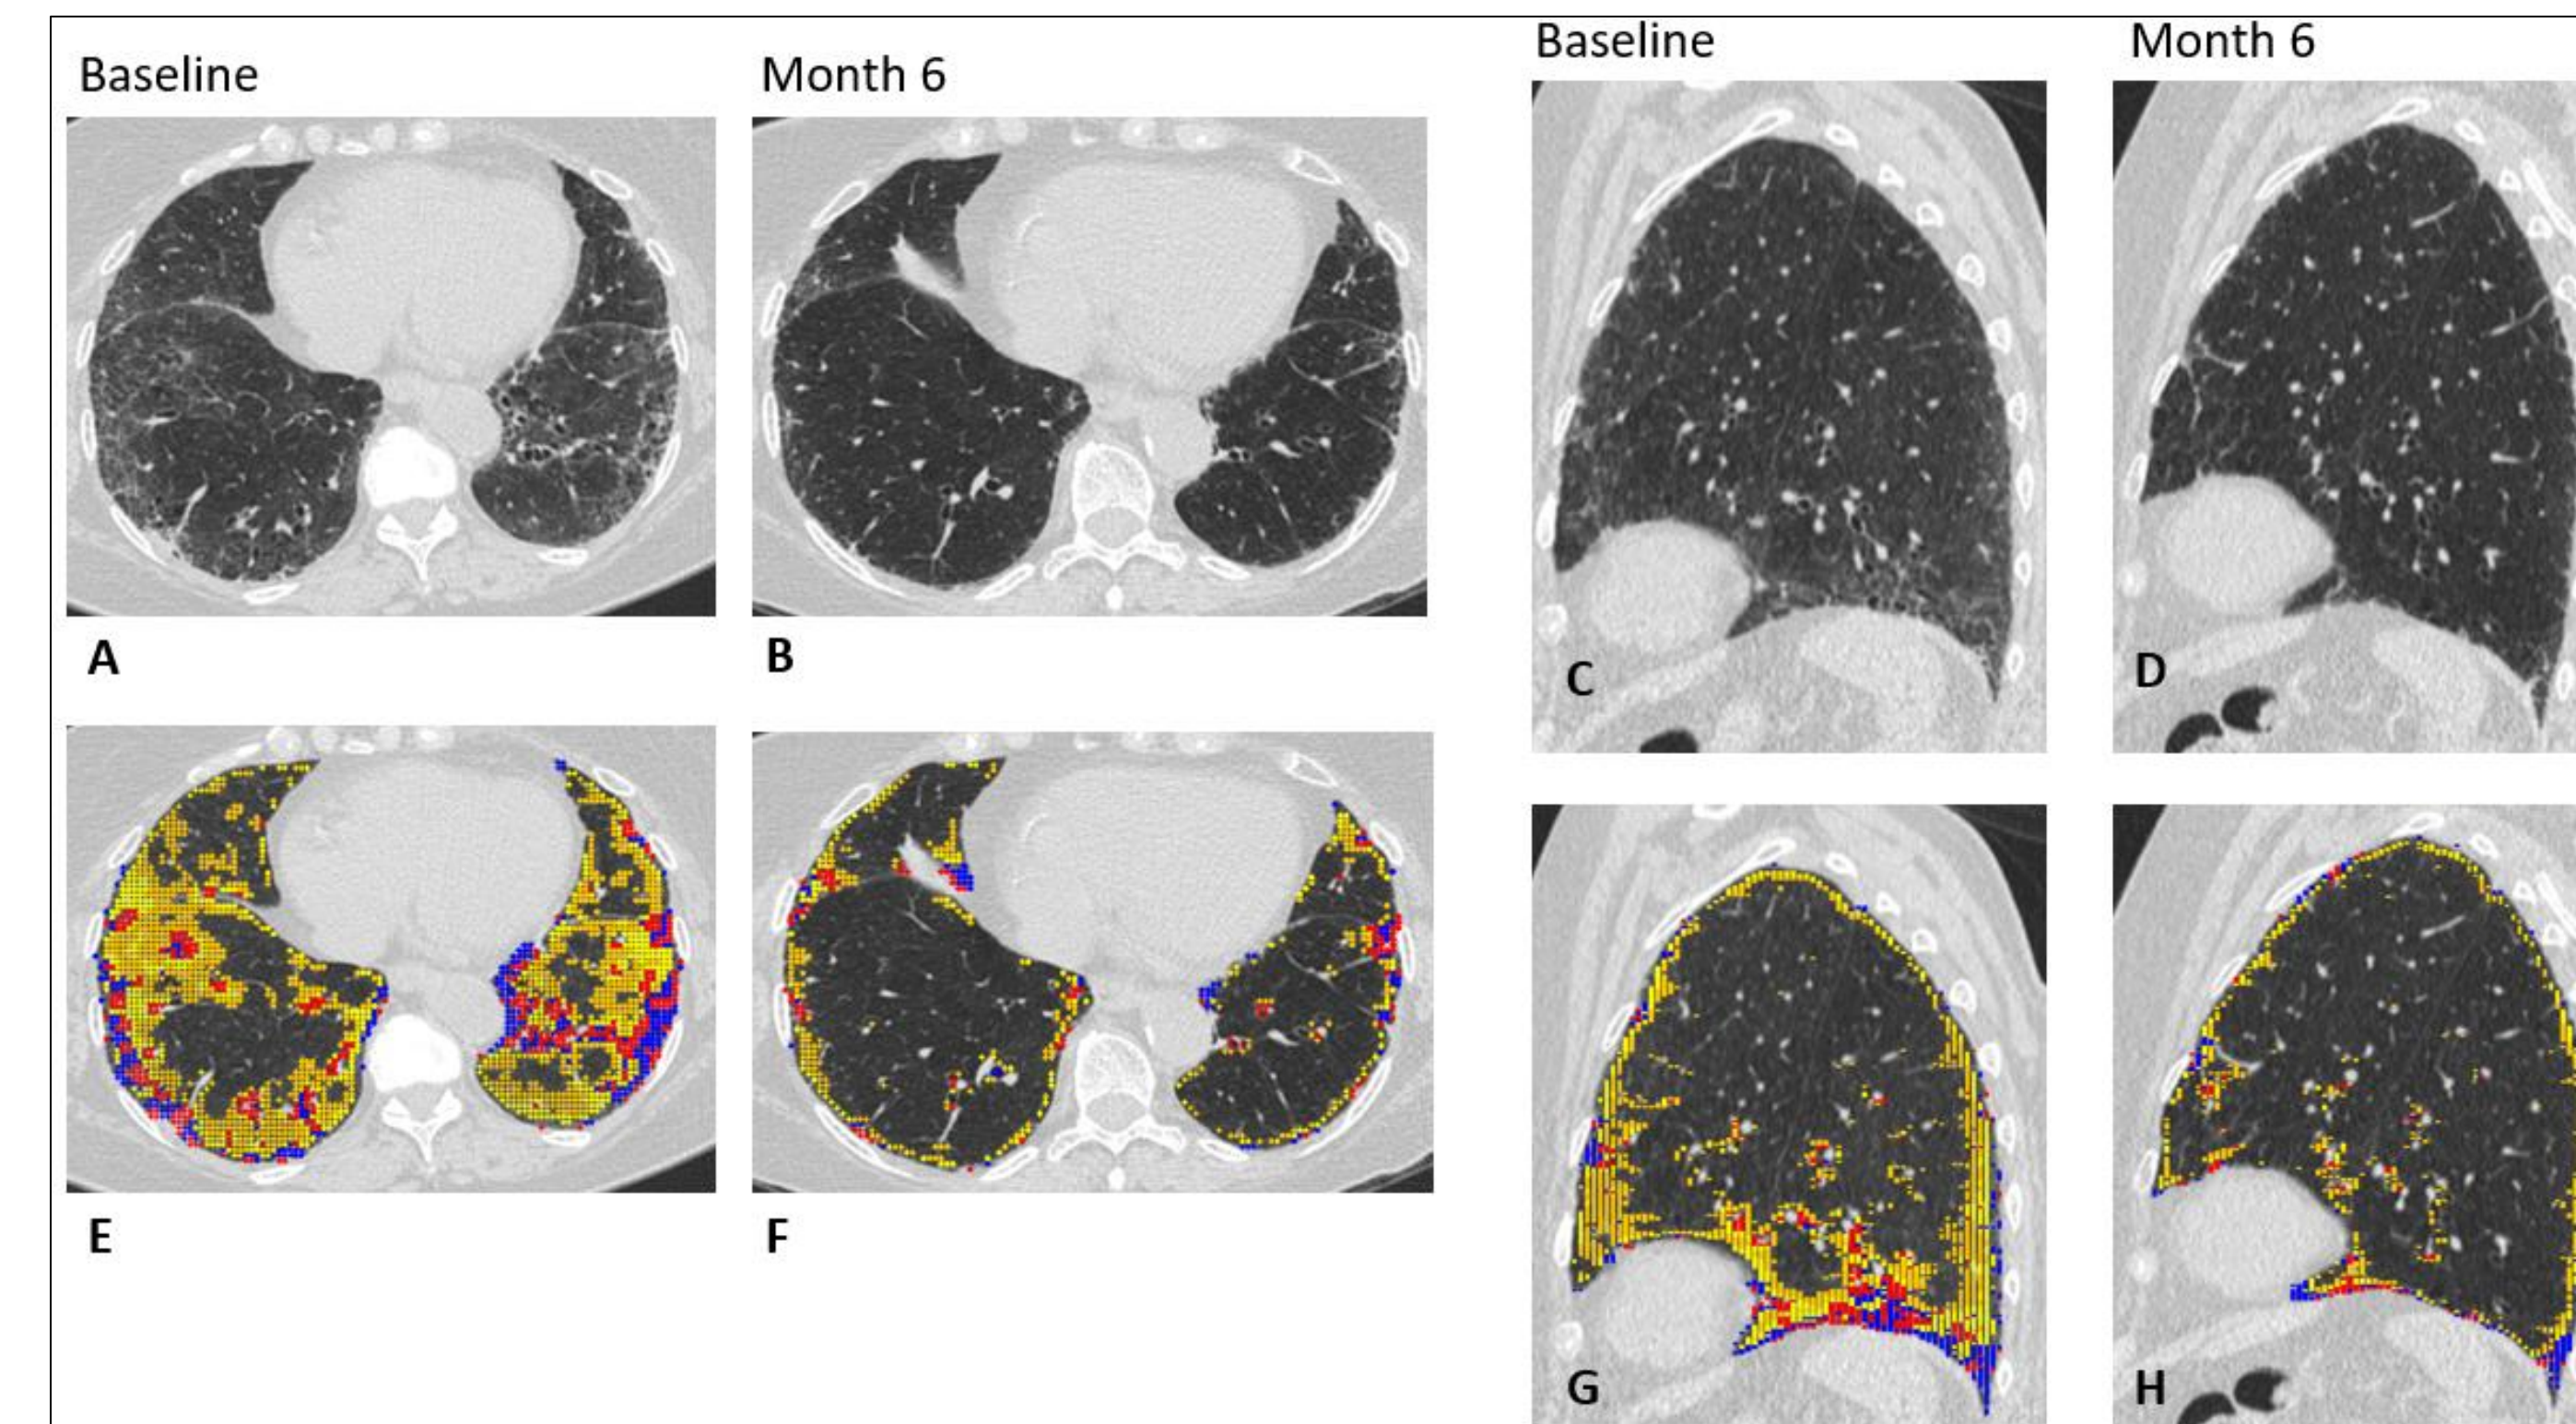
SuperResponder examples. A, B, C, and D: axial and sagittal HRCT images; E, F, G, and H: overlaid quantitative results of the corresponding images of A, B, C, and D. Blue and red dots indicate the results of QLF classification; yellow dots indicate the ground glass. A and C: from the baseline CT. B and D: from the 6-month follow-up CT scans.
